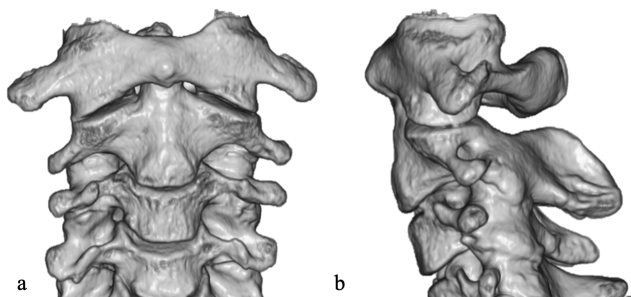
5B. Post-reduction three-dimensional computed tomography of case 2 shows disappearance of C1-C2 sublaxation.
